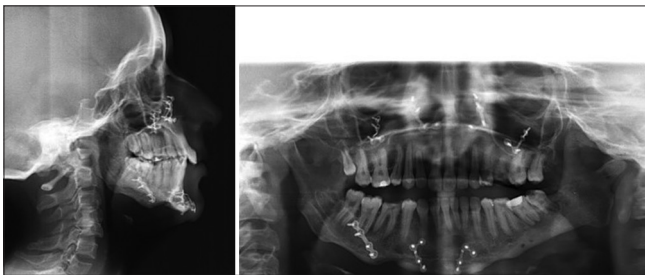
One year follow-up radiograph
